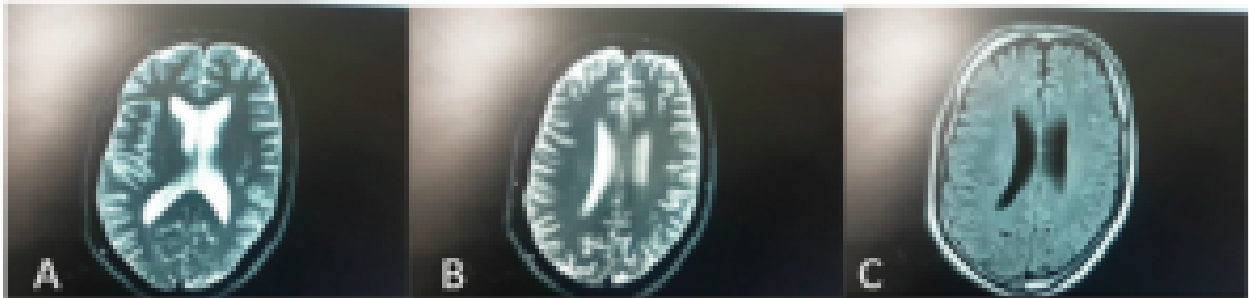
Brain magnetic resonance imaging with diffusion-weighted imaging.¹
